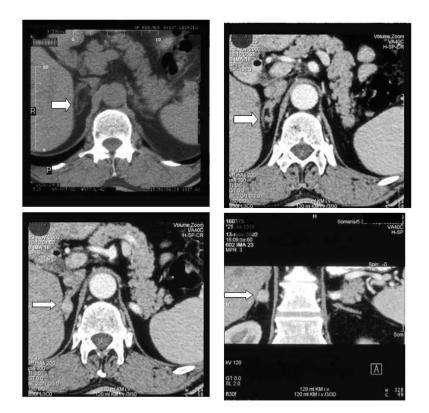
Conn adenoma. Appearance of a 1 cm right-sided adrenal nodule (arrow) on contrastenhanced computed tomography in a middle-aged man with hypertension treated for 20 years, initially only with a betablocker before becoming medically refractory and hypokalemic with inappropriate kaliuresis. After laparoscopic right adrenalectomy, the patient required only one antihypertensive drug to control his blood pressure.
